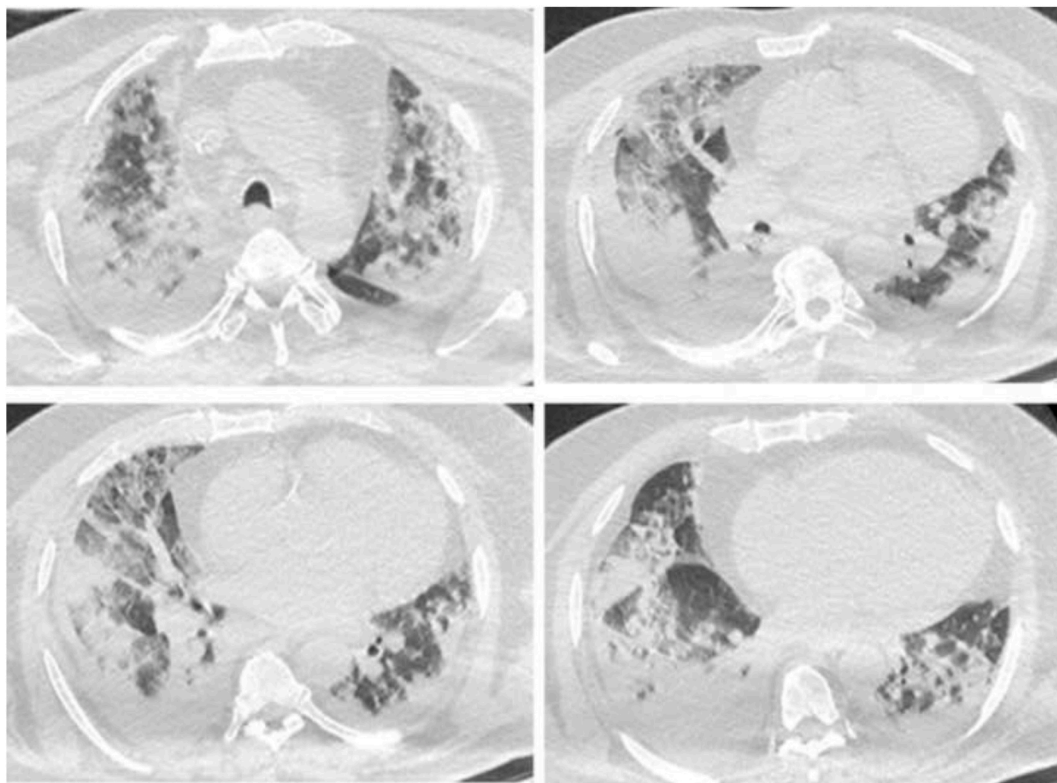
Computed tomography chest on day 1 showing multiple areas of consolidation of the lung parenchyma with a predominance of the lower lobes and ground glass opacities that predominate in both upper lobes with thickening of the alveolar septa.
